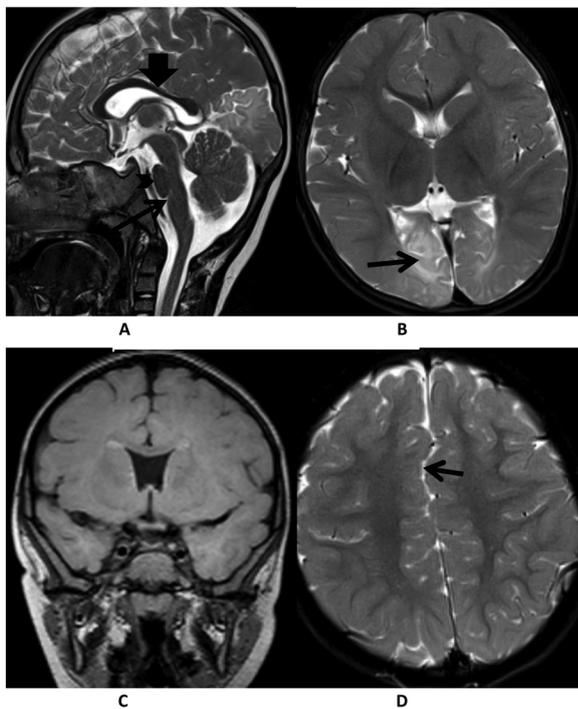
MR images of the patient; Sagittal T2 weighted image (A) shows abnormally marked pontobulbar sulcus (arrow) associated with pontine hypoplasia (arrow head), and thin corpus callosum (thick arrow). Axial T2 weighted image (B) reveals increased signal and atrophy in the white and gray matter of the occipital lobe (arrow). Coronal T1 weighted image (C) shows absence of interventricular septum. Axial T2 weighted image (D) shows mild interdigitation of gyri across the interhemispheric fissure (arrow).
